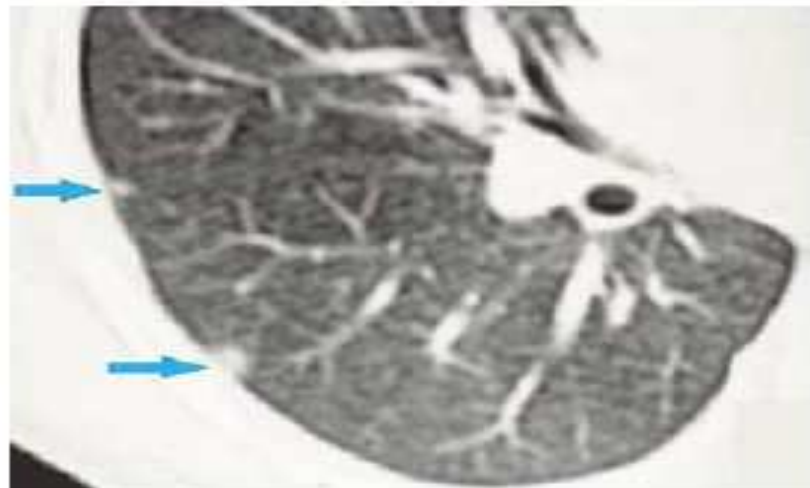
High-resolution CT of a 12-year-old demonstrating subpleural pulmonary nodules (arrows).
